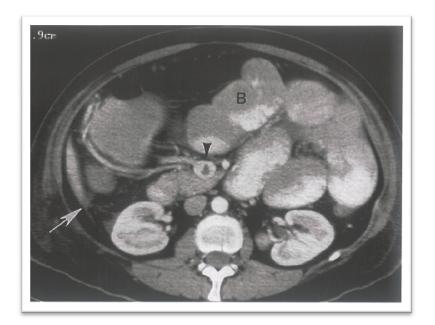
13 CT – abdomen shows block in superior mesentery artery
